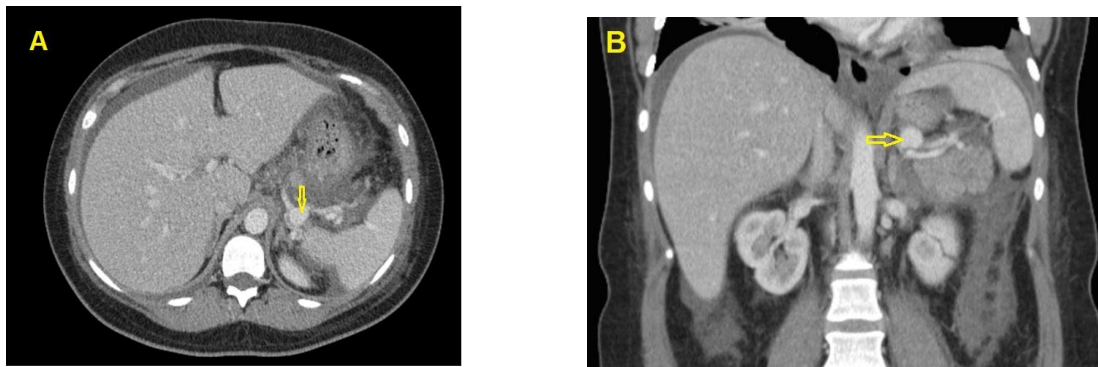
Contrast enhanced Abdominal CT (A) transverse view, (B) coronal view both showing splenic arterial pseudoaneurysm (SAP) , arrow.
